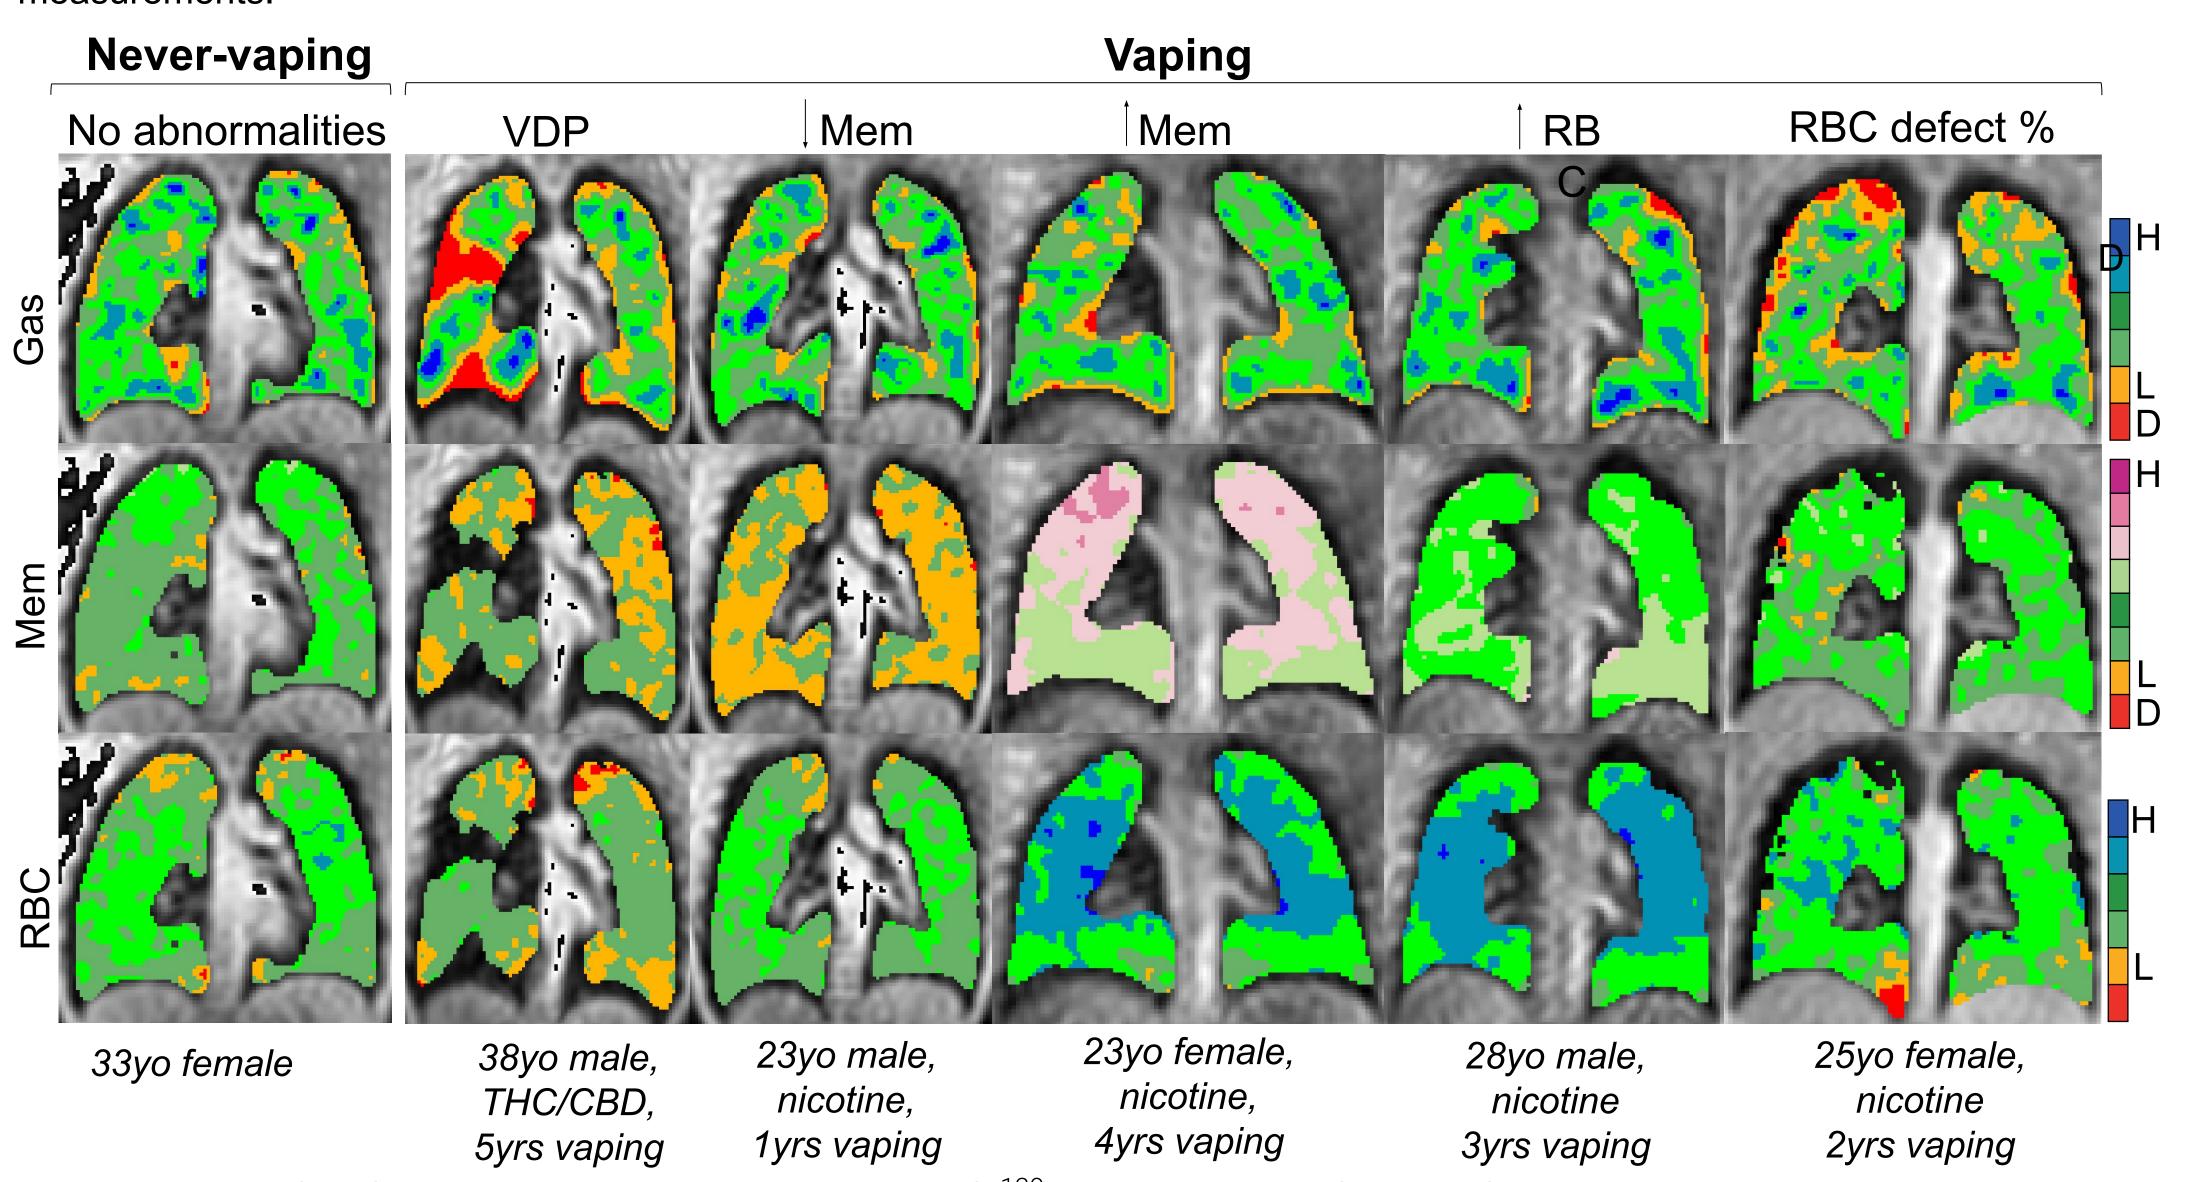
Further by participant inspection revealed ¹²⁹Xe MRI gas exchange abnormalities in vaping participants. D=defect (no signal); L=low signal; H=high signal.
